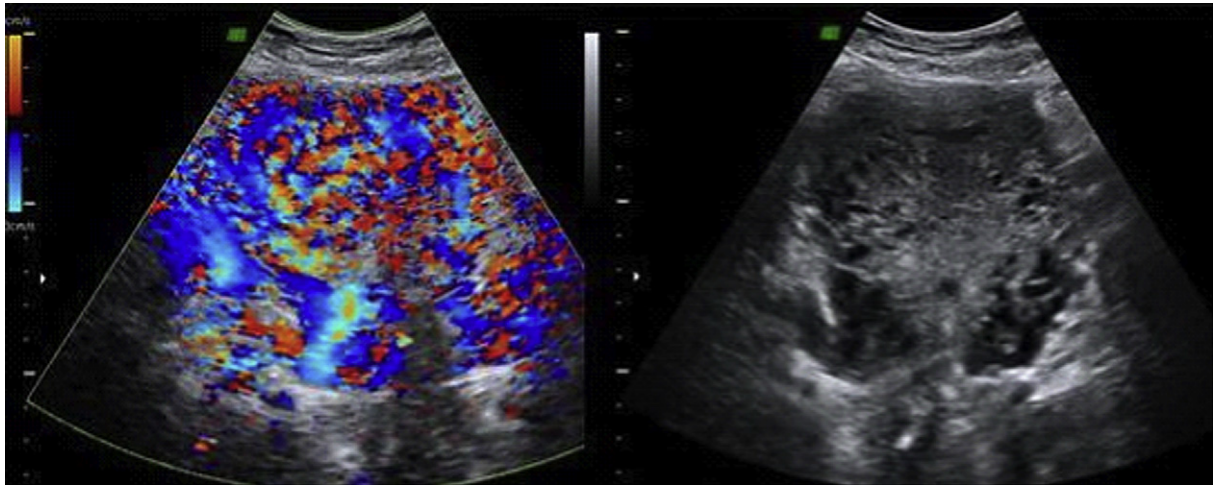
A 100 mm × 90 mm × 75 mm size pelvic mass was not distinguished from uterine wall. Doppler velocimetry of the mass showed increased blood flow, which was considered to be malign.
